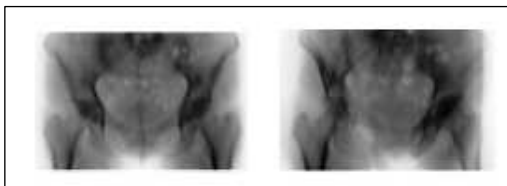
Samples of DRR images generated from pelvis CT volume, using parallel processing.
